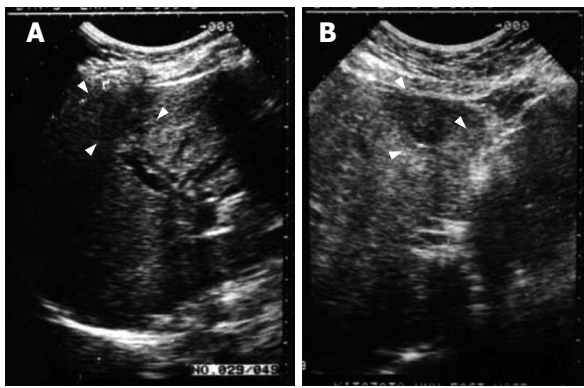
Ultrasonography findings of the liver. A: Dilatation of the intrahepatic ducts and a hypoechoic mass in the right lower anterior segment; B: A heterogeneous mass in the inner left segment.
